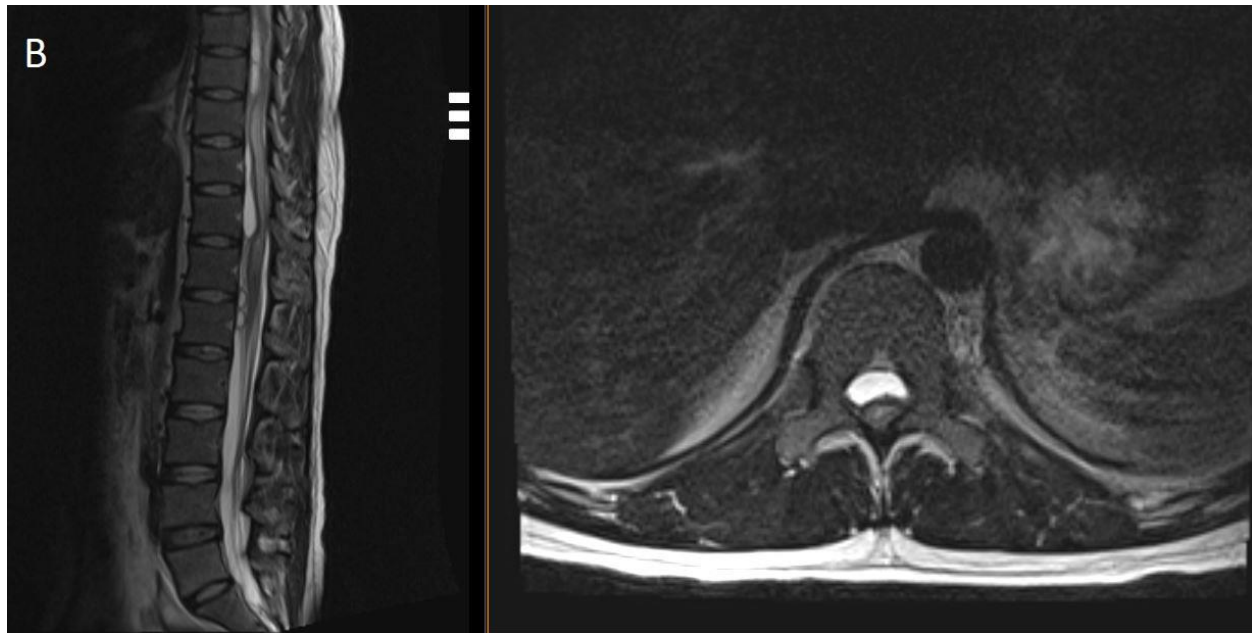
T2-weighted sagittal and axial MRI of the spine at the A.) C7-T1 and B.) T11 levels revealing right-sided hyperintense, cystic lesions with notable mass effect on the spinal cord with associated signal change.
